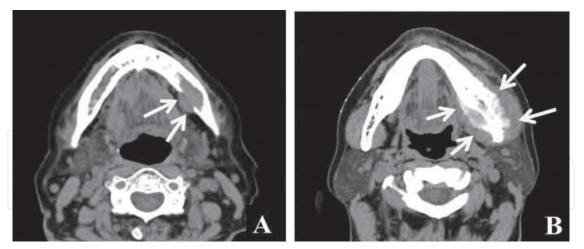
Axial CT images (A, B) of a metastatic mass (arrows) in the mandible.
